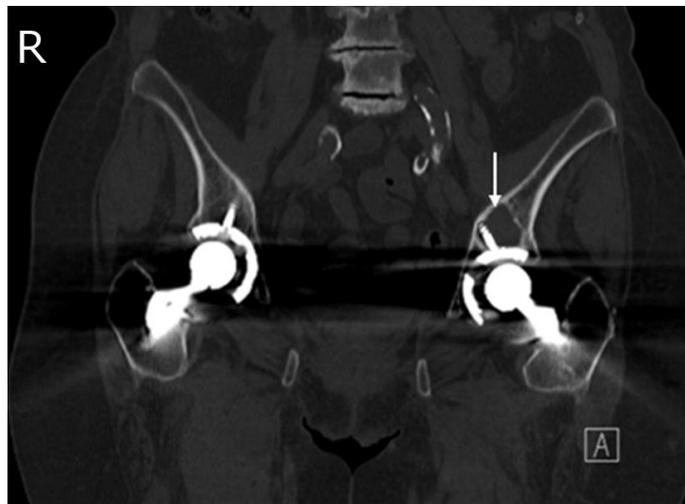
(left): An 80-year-old female with particle disease. Prosthetic hardware appears intact bilaterally on this coronal CT. A well-defined lucency tracking superiorly from the left acetabulum along the vertical aspect of the left iliac bone is noted (arrow). On another slice, this was seen to extend superiorly up well into the left iliac wing. Particle disease has a tendency to track along the screw. There is no lucency in the right iliac bone. [2.0 mm coronal CT reconstruction acquired at 140 kVp and 162 mAs on a GE 16-slice scanner, no contrast]
